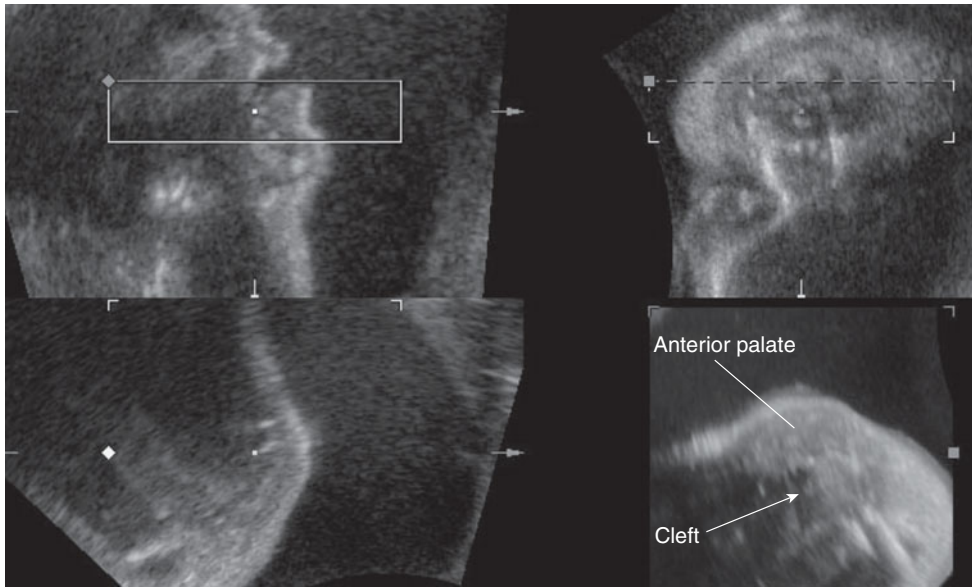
3D sonographic diagnosis of cleft palate. (Reproduced, with permission, from Benacerraf BR, Sadow PM, Barnewolt CE, Estroff JA, Benson C. Cleft of the secondary palate without cleft lip diagnosed with three-dimensional ultrasound and magnetic resonance imaging in a fetus with Fryns' syndrome. *Ultrasound Obstet Gynecol.* 2006;27[5]:566–570.)
